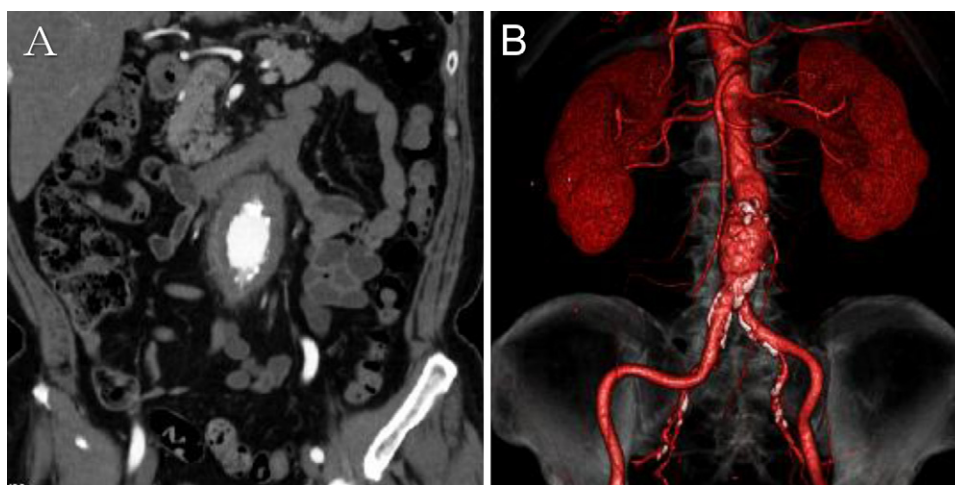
A 57-year-old man presented with repetitive epigastralgia. Coronal sections of computed tomography (CT) scanning images. (A) Dense soft tissue surrounding the mildly dilated abdominal aorta can be observed. (B) 3D reconstruction of the CT images. Calcification of the wall of the aorta and common and internal iliac arteries observed. In this patient, corticosteroid therapy reduced clinical symptoms and periaortic soft tissue. Serum IgG4 level was not elevated in this case. Details in this case have been reported elsewhere [77].
